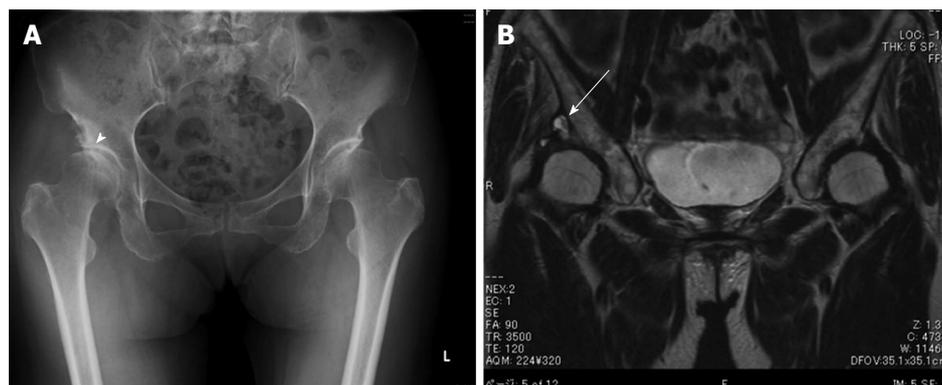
A 70-year-old female with a cystic lesion associated with osteoarthritis. Plain radiograph of the lower pelvis reveals the secondary osteoarthritis of right hip due to acetabular dysplasia (arrowhead) (A). Coronal T2-weighted magnetic resonance image shows a cystic mass (arrow) located superiorly, connected to the right hip joint (B).
